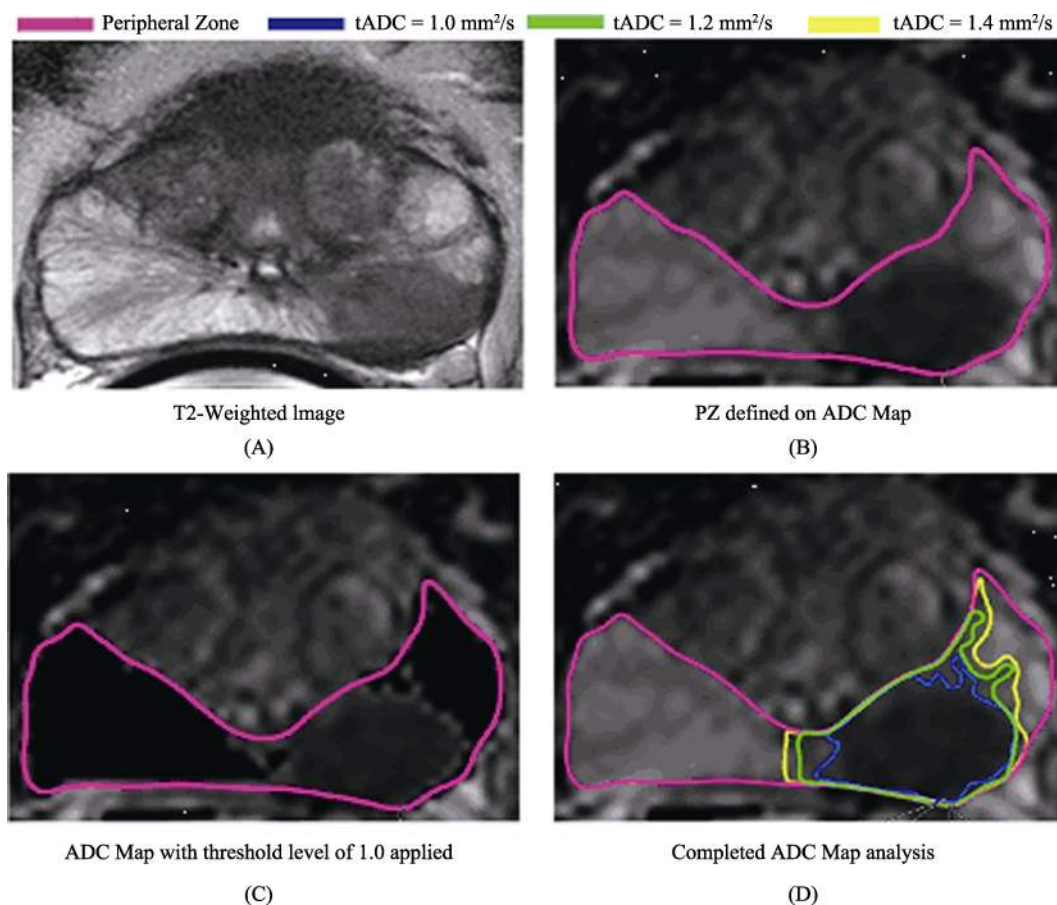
Representative image for each step of the data analysis process. (A) T2-weighted axial image for anatomical identification of the peripheral zone; (B) corresponding apparent diffusion coefficient (ADC) map and outline of the peripheral zone; (C) pixel values above the applied $1.0 \times 10^{-3} \text{ mm}^2/\text{s}$ tADC appear black on the ADC map, leaving the outline of a potentially malignant lesion; (D) representation of the superimposed lesion area identified at each ADC threshold (tADC) value
